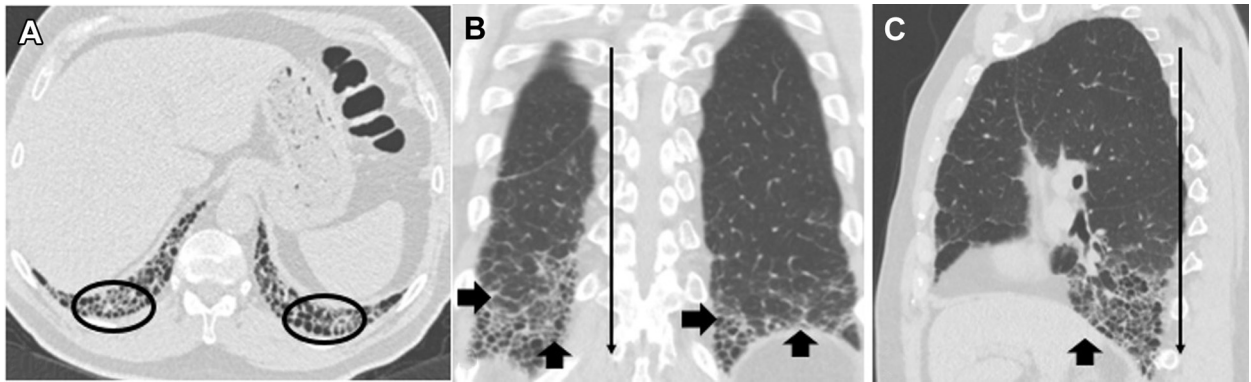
CT scan of the chest in axial (A), coronal (B), and sagittal (C) views in a patient with typical usual interstitial pneumonia pattern. A, honeycombing at bilateral bases in a craniocaudal gradient and predominantly reticular pattern (B, C).
